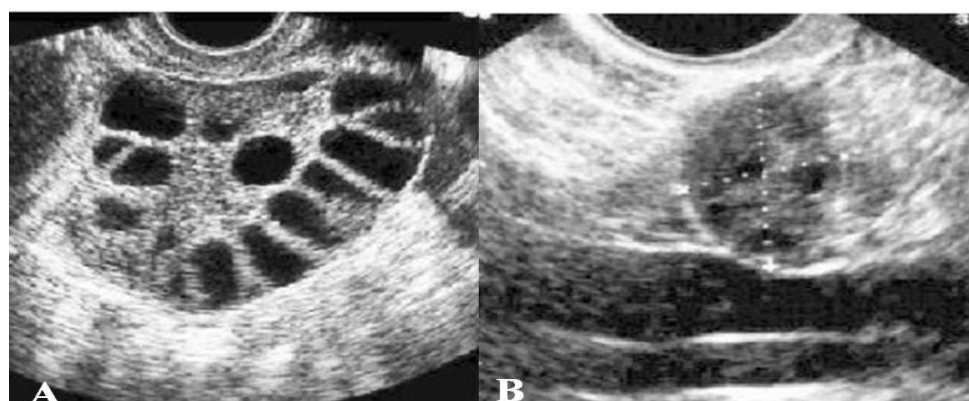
Polycystic ovarian syndrome by ultrasonography images [19].
